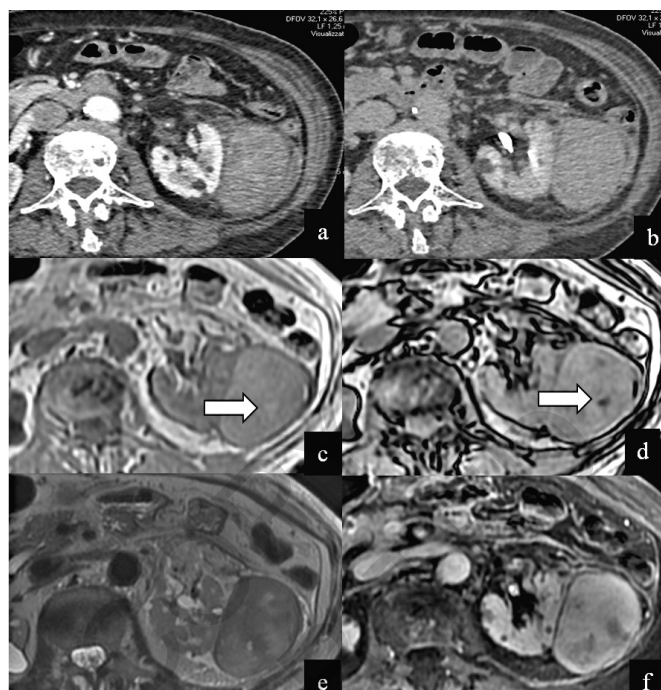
De-differentiated liposarcoma. Axial portal phase (a) and delayed phase (b) contrast-enhanced CT images, axial in-phase (c) and out-phase (d) T1-weighted, axial T2-weighted (e), and contrast-enhanced axial T1-fat saturation (f) MRI images show left perirenal mass. In-phase (c) and out-phase (d) T1-weighted MRI images demonstrate fat content (arrows in c and d) that is invisible on CT, and in the other MRI sequences.
